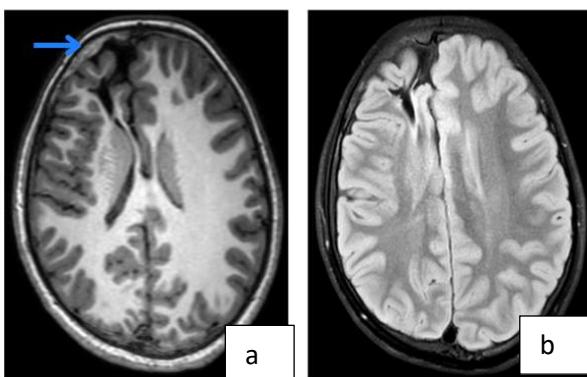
(a and b): MRI brain showing encephalomalacia and asymmetry in size of cerebral hemispheres.
